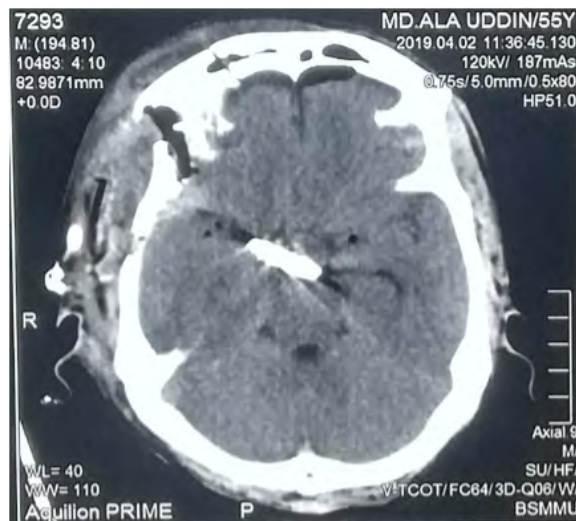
CT scan revealed no postoperative intracranial hematoma and the surgical clip was in the proper location.
